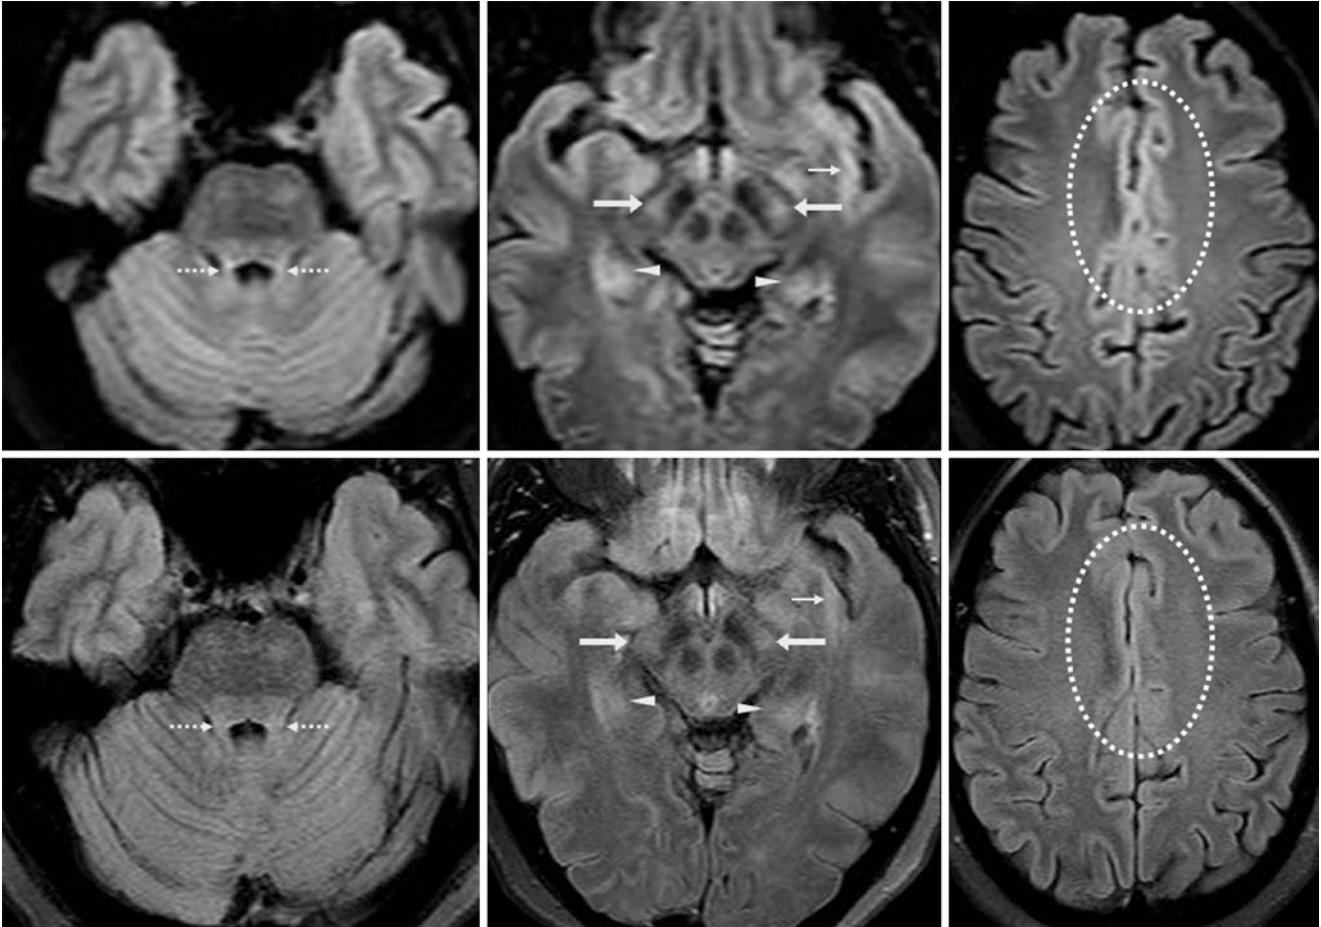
In a 53-year-old, axial reformat from a 3D FLAIR acquisition at 3 T (*top row*) show normal hyperintensity in various sites, being brighter than 2D FLAIR images from 2 years prior (*bottom row*). Bright
